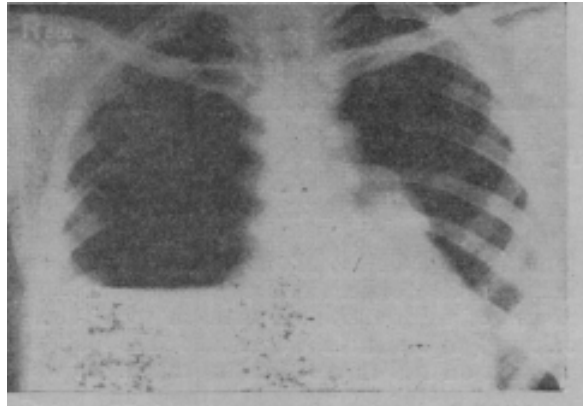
Plain X-ray of Chest showing
